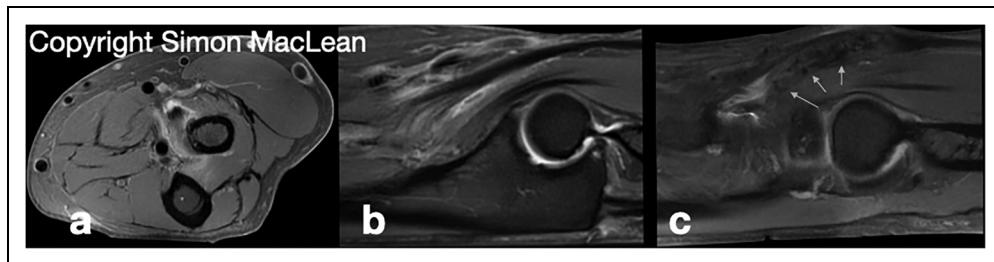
A partial 'peel-off' tear with the entire lateral-sided short and long head involved (a – axial, b – sagittal sequences). The entire tendon was identified to be degenerate at surgery. A release, tuberosity debridement and repair were performed. The patient remained symptomatic with pain and weakness. A post-op MRI at 6 months showing attenuated but attached heterogeneous tendon stump (c). Copyright Mr Simon MacLean. MRI: magnetic resonance imaging.
